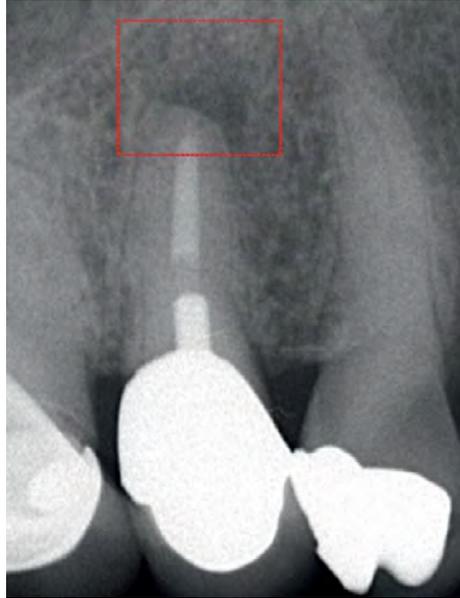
Periapical Radiolucency on an Image without AI Definition
